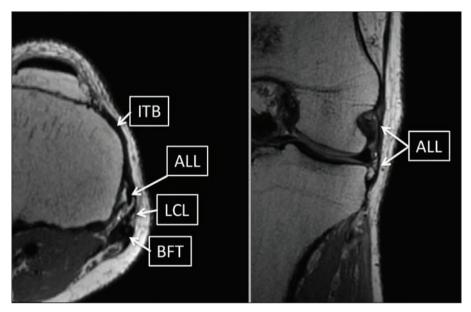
MRI of the ALL. 3D 1 mm-section MRIs, T2-weighted images. Axial and coronal multiplanar reconstructions. ALL: anterolateral ligament, ITB: iliotibial band, LCL: lateral collateral ligament, BFT: biceps femoris tendon.
